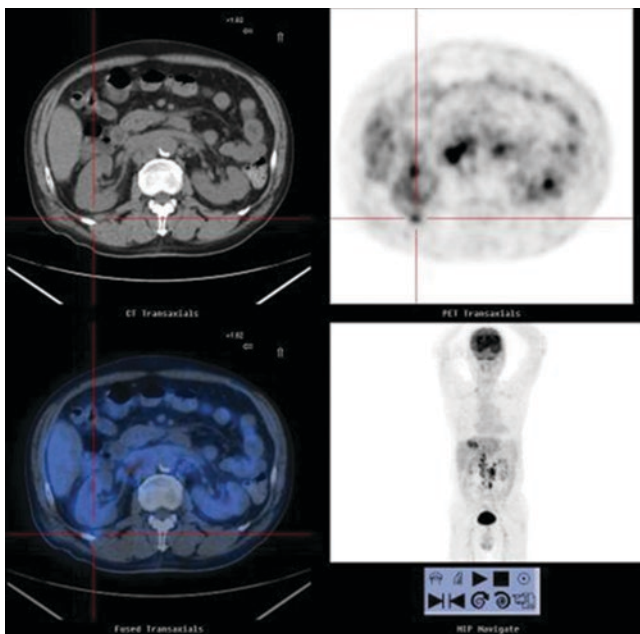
PET/CT—Nodule shadow of right posterior abdominal wall, metabolism increased, malignant lesions metastasis is not excluded
